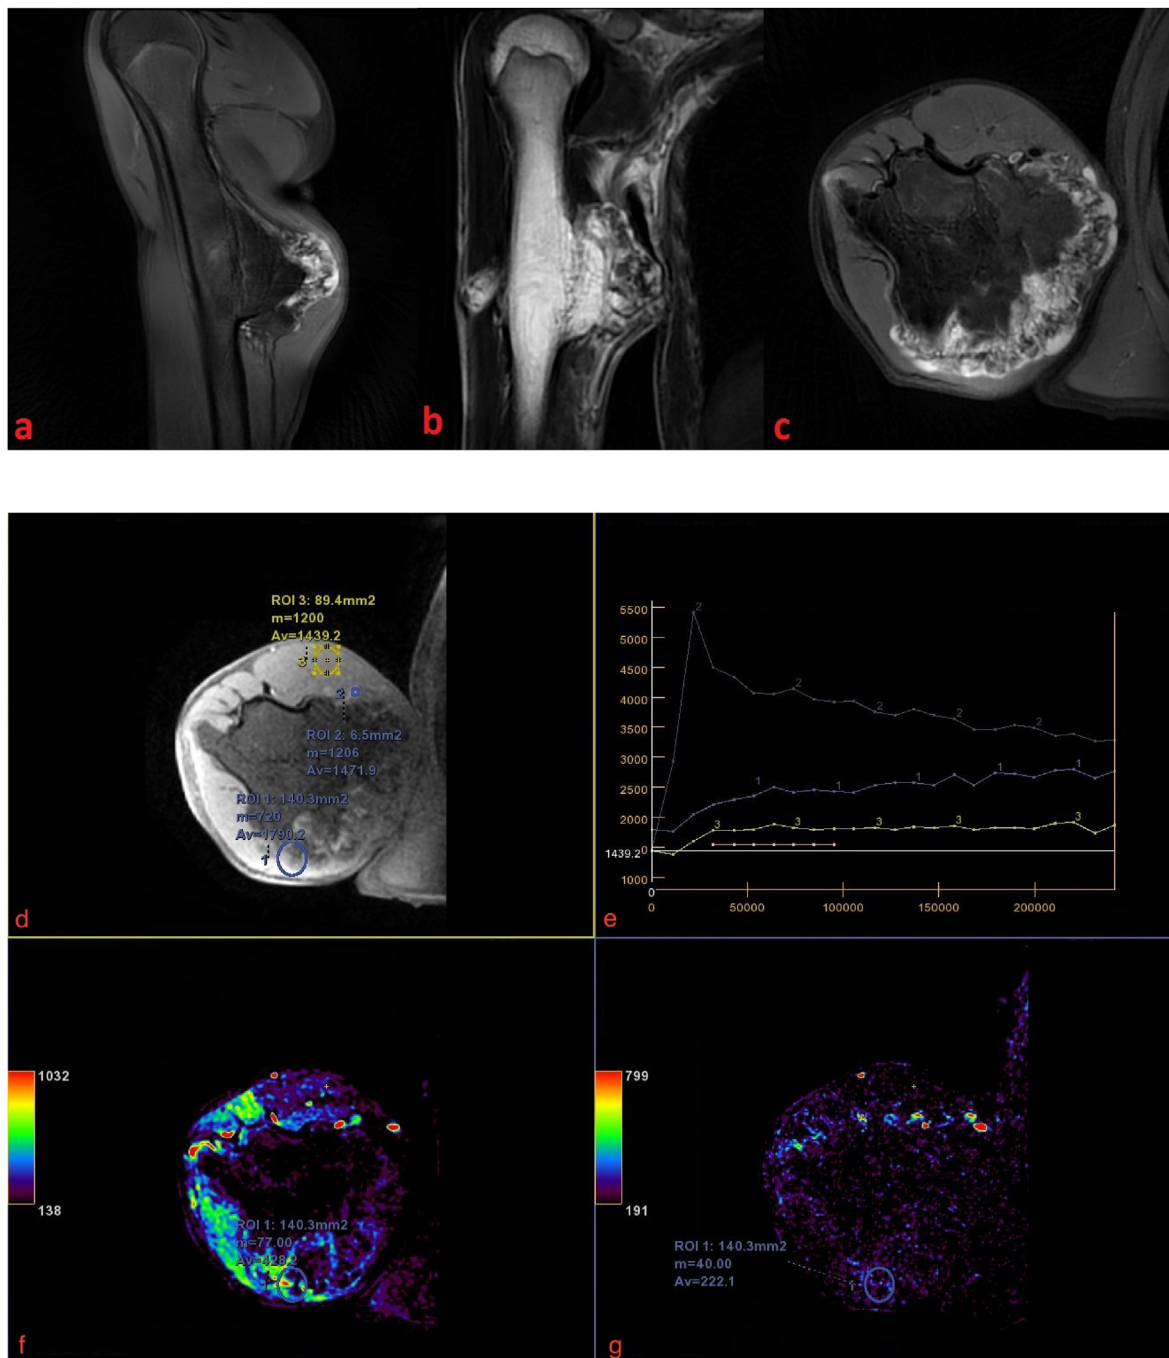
Conventional MRI images of a 13-year-old patient presented with a recent increase in the size of a previously stable lesion. Sagittal PDFS (a), coronal T2FS (b) and axial PDFS (c) shows a board based lesion arising from the diaphyseal region of humerus with medullary continuity with the shaft. Overlying cartilage cap is seen which appears thickened (3 cm in maximum thickness) and shows heterogeneous signal intensity on T2/PDFS images.
